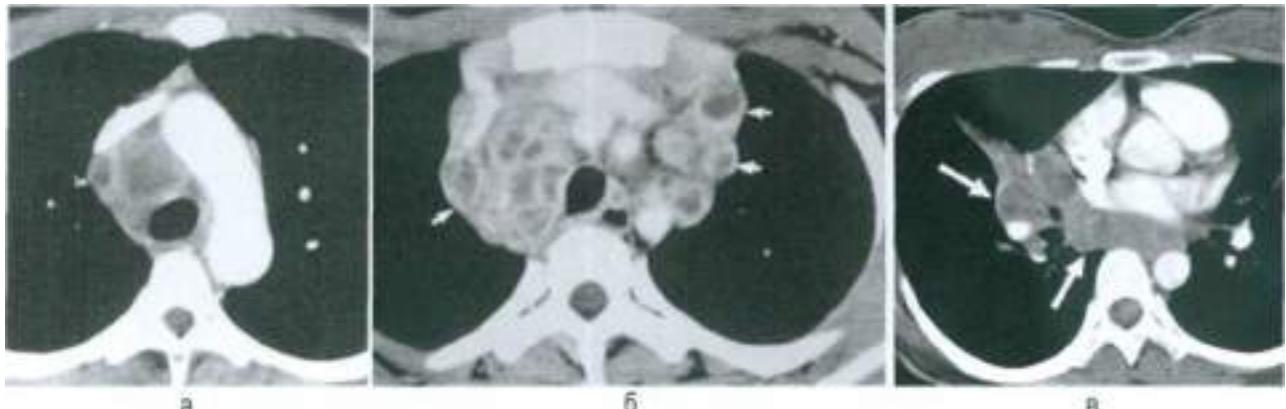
Intrathoracic lymph node tuberculosis, developmental stage. CT angiography.
